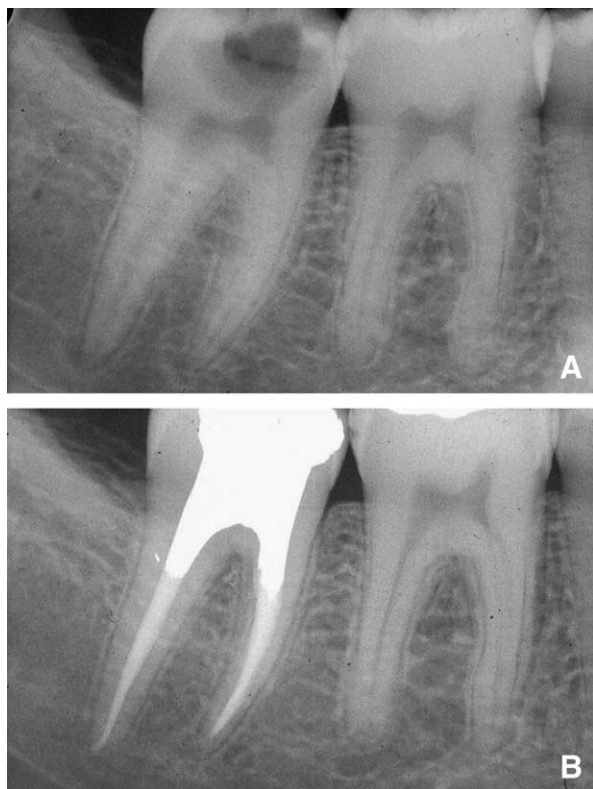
Preoperative (A) and 2-year postoperative (B) recall radiographs of tooth #31. A small radiolucency was present preoperatively on the distal root.
